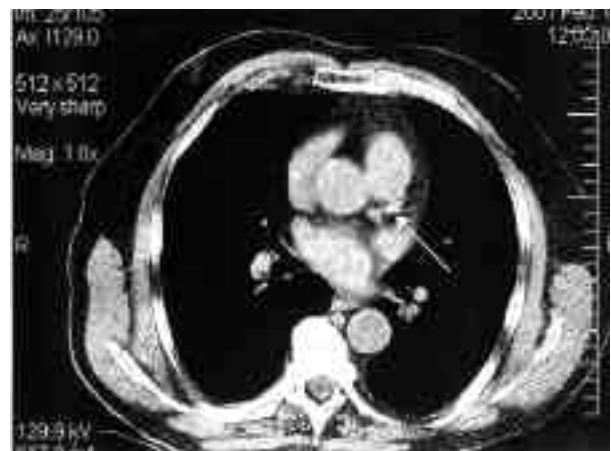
Electron beam CT scan demonstrating calcification (arrow) in the left anterior descending artery (arrow).
